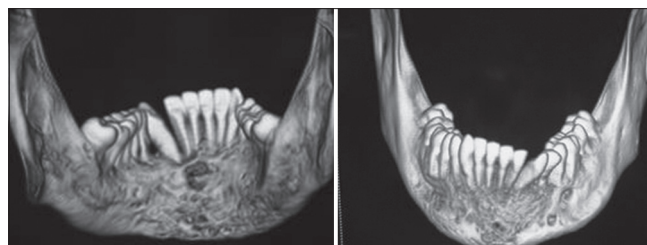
Bone density and cone beam CT Scan (CBCT) showing severe mandibular radiolucency and alveolar bone resorption associated with severe vitamin D deficiency in an 18-year-old adolescent
